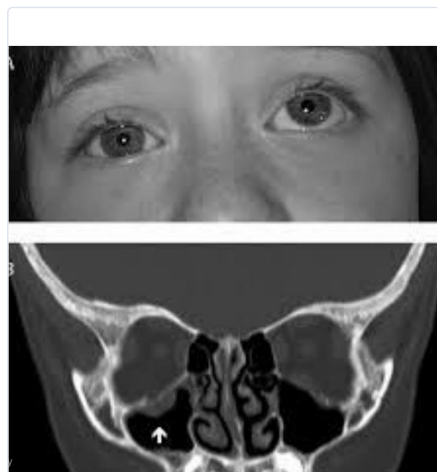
Orbital blow-out. A: clinical restriction of upgaze. B: coronal CT — orbital contents herniating through the floor into the antrum (arrow), the "hanging drop".
